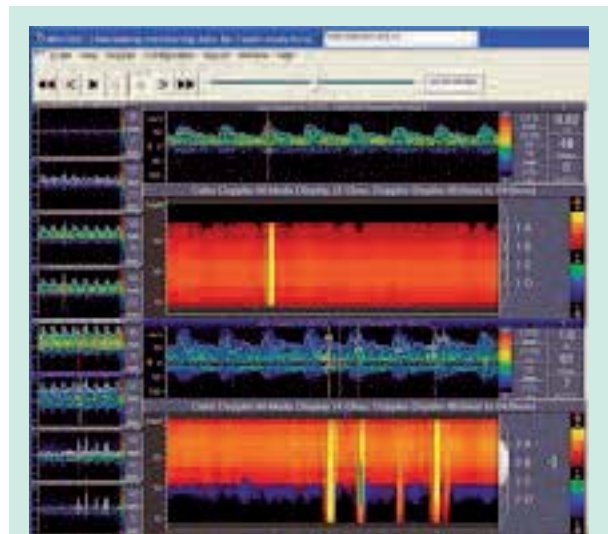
Transcranial Doppler tracing of middle cerebral artery in an immobile patient 15 minutes after being injected with 3mL of 1% foamed sclerosant into a 2mm peripheral leg vein under ultrasound guidance. The patient remained immobile following the injection, and then carefully (to avoid disruption of the TCD monitoring device) sat up. Several emboli can be identified in the middle cerebral artery (lower row 2A-2D).
